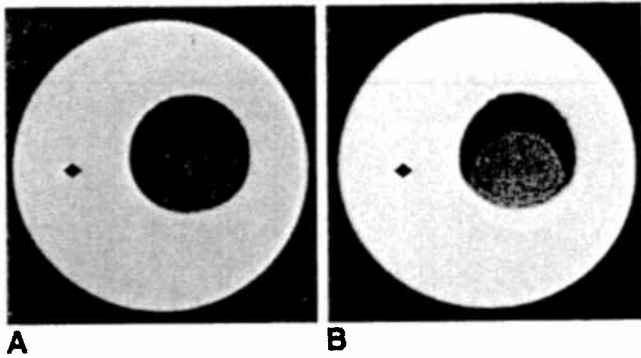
MR images of a vial of silicone oil in a water bath.
